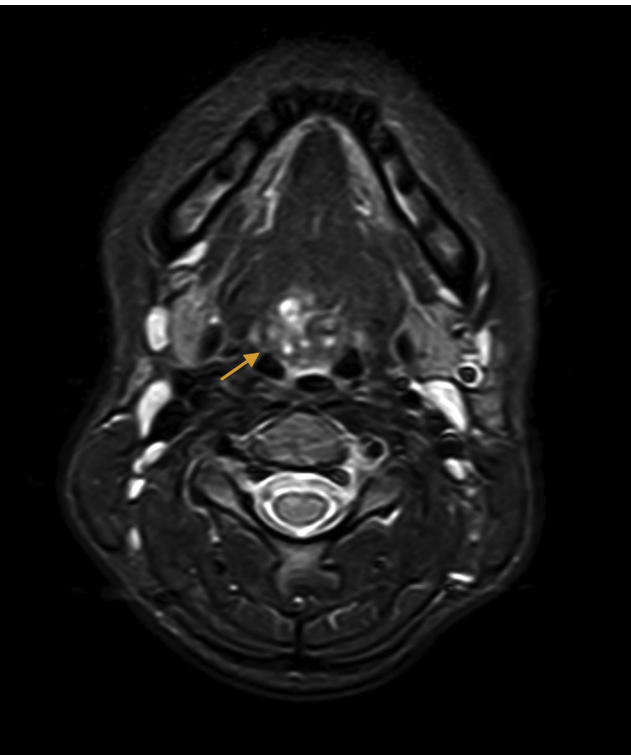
Magnetic resonance imaging T2 FAT SAT sequence on the axial plane showing thyroid tissue at the base of tongue (indicated by arrow).
